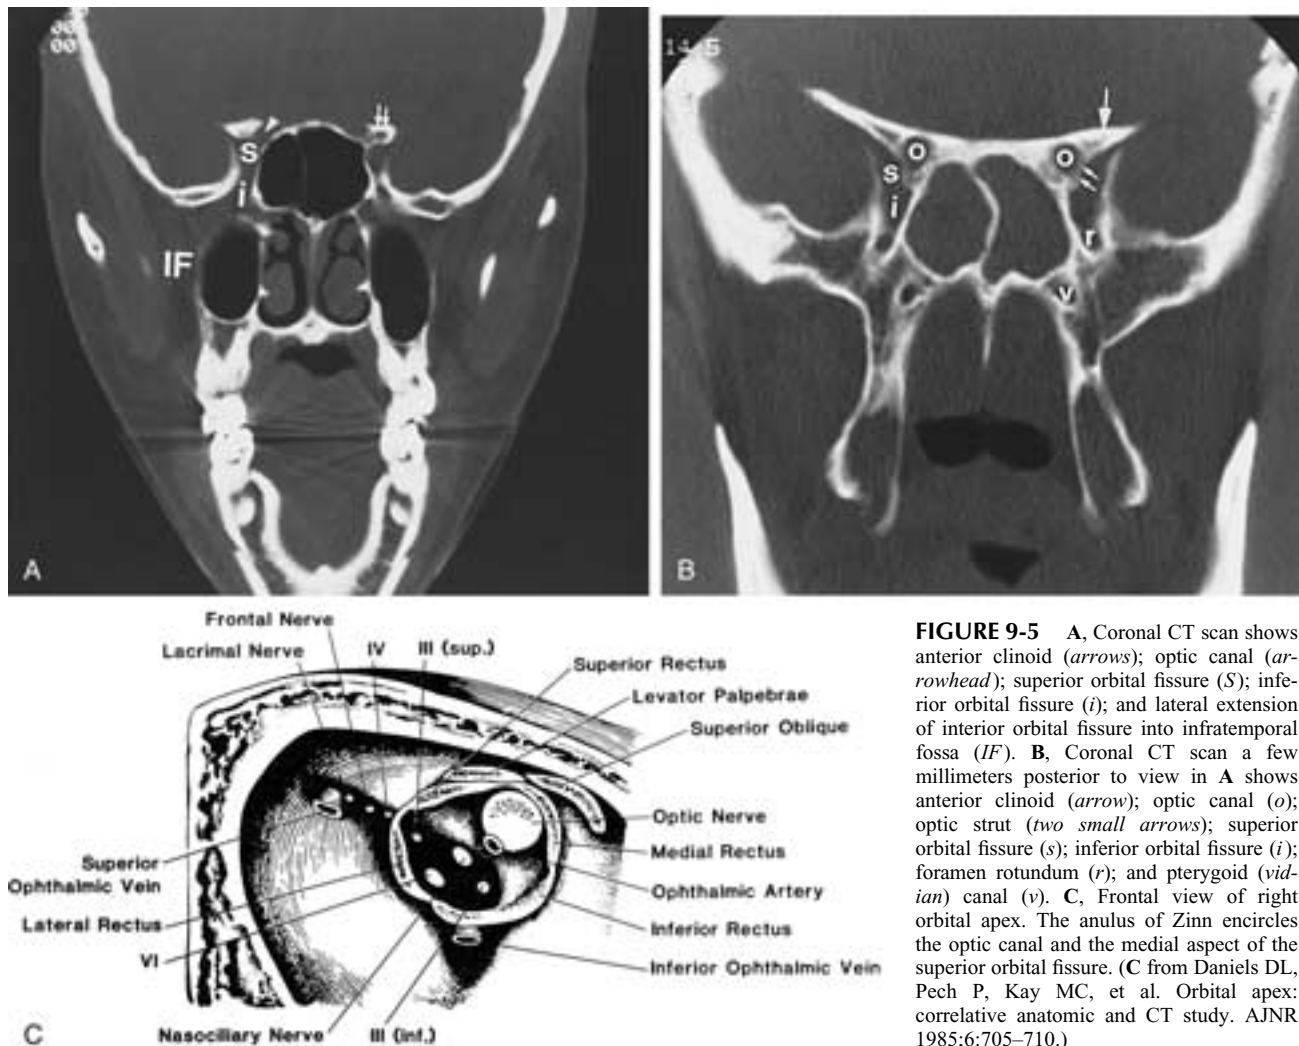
A, Coronal CT scan shows anterior clinoid (arrows); optic canal (arrowhead); superior orbital fissure (S); inferior orbital fissure (i); and lateral extension of inferior orbital fissure into infratemporal fossa (IF). B, Coronal CT scan a few millimeters posterior to view in A shows anterior clinoid (arrow); optic canal (o); optic strut (two small arrows); superior orbital fissure (s); inferior orbital fissure (i); foramen rotundum (r); and pterygoid (vidian) canal (v). C, Frontal view of right orbital apex. The anulus of Zinn encircles the optic canal and the medial aspect of the superior orbital fissure. (C from Daniels DL, Pech P, Kay MC, et al. Orbital apex: correlative anatomic and CT study. *AJNR* 1985;6:705-710.)
